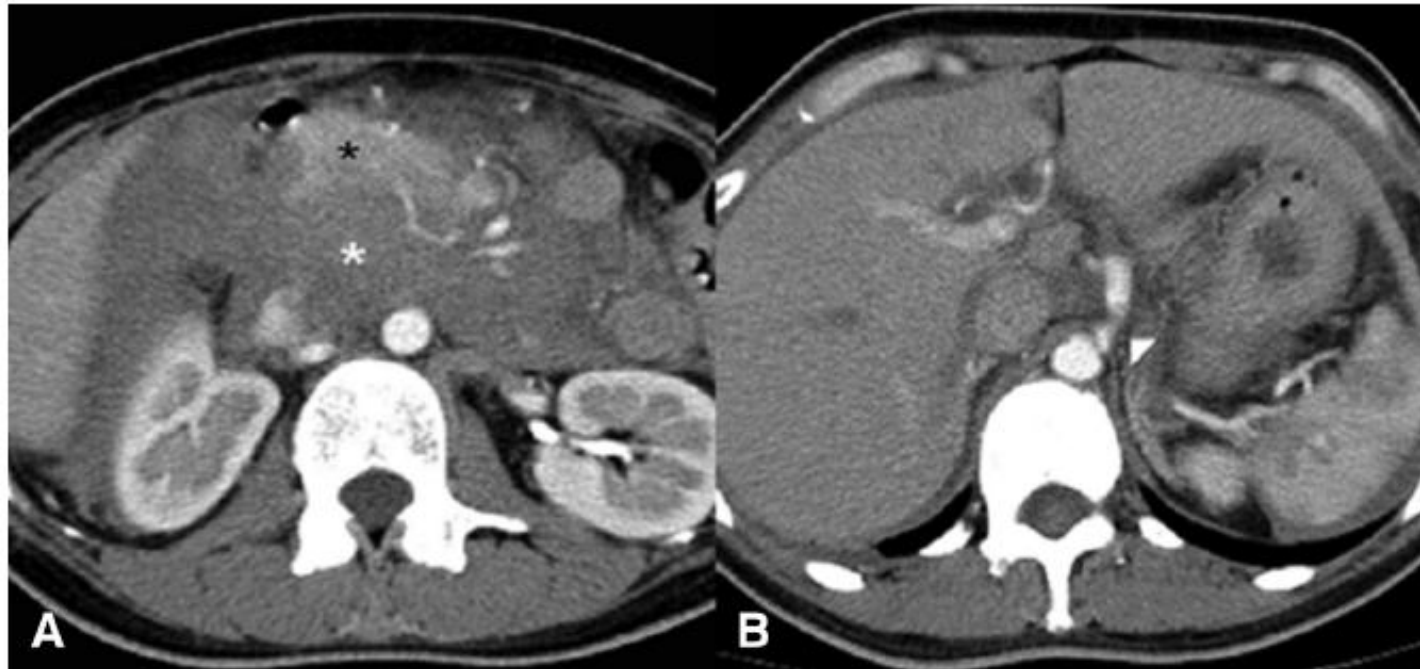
Abdominal contrast-enhanced computed tomography scan demonstrating (A) a massive retroperitoneal hematoma (white asterisk) surrounding the pancreas (black asterisk) over the retroperitoneal space and (B) celiac artery stenosis (arrowhead) and post-stenotic dilatation.
